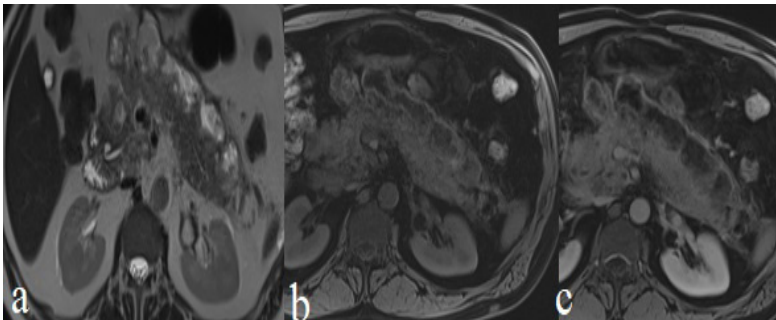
A man patient aged 45 with a WON. Mixed T2WI (a) and T1WI (b) signal intensity with an irregular collection. Heterogeneous contrast enhancement is seen on the MRI image (c).
